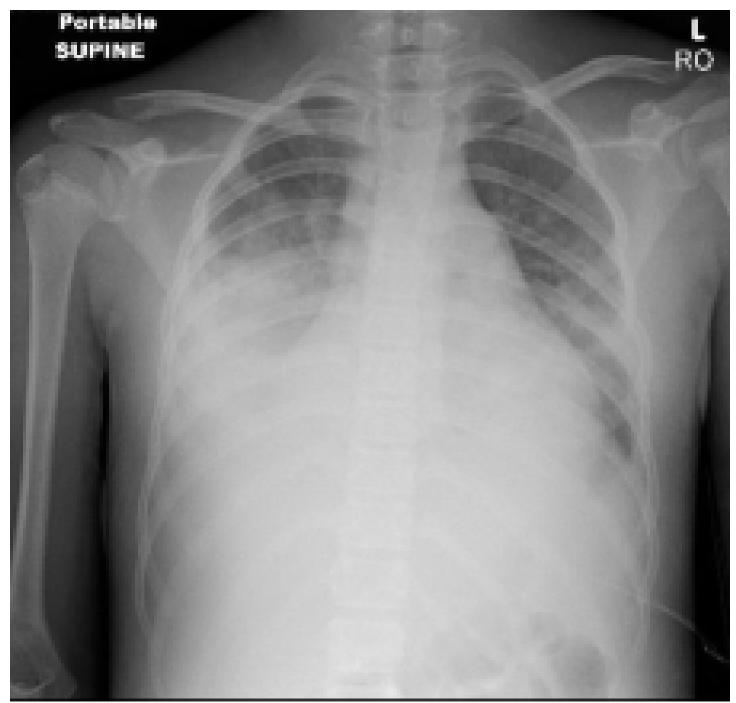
Portable supine chest radiograph on the fourth day of admission, showing progressed, right greater than left, bibasilar opacities and bilateral pleural effusions.
